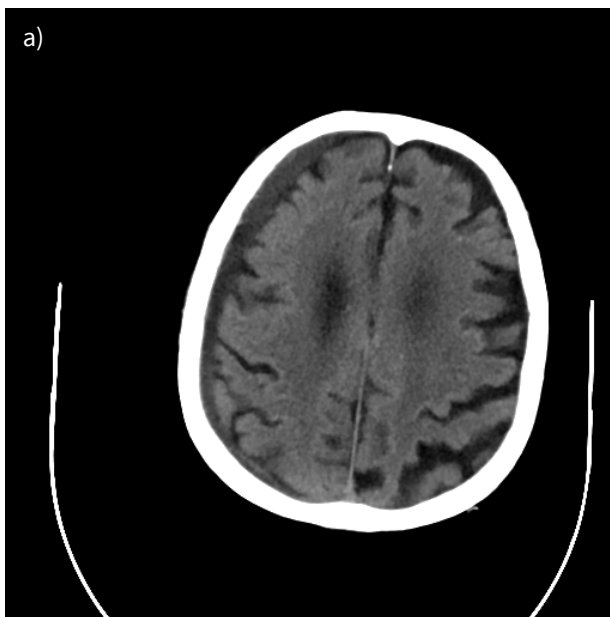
Postoperative native axial head CT showing a satisfactory hematoma resolution and the right brain hemisphere reexpansion (a), as well as reestablishing of normal ventricular configuration with no midline shifting (b).
